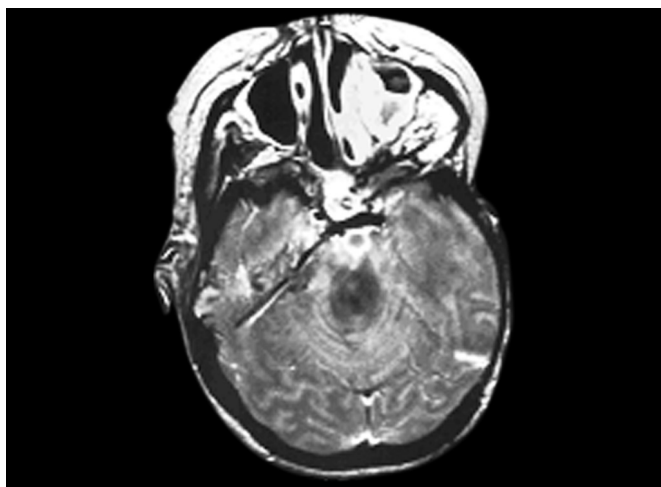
Magnetic resonance imaging (MRI) showing tumor invasion of skull base, foramen lacerum, and posterior aspect of cavernous sinus of a 39-year-old woman with adenocarcinoma of the skull base.
